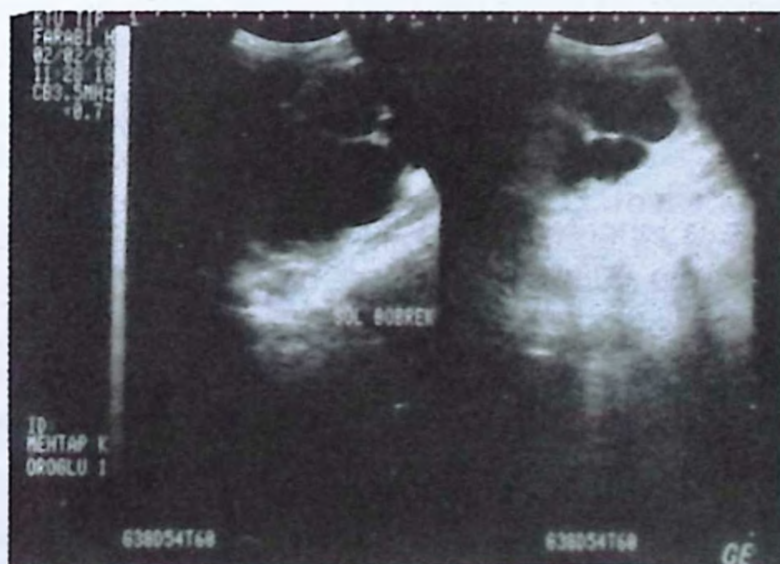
Ultrasonography shows hydronephrosis.
